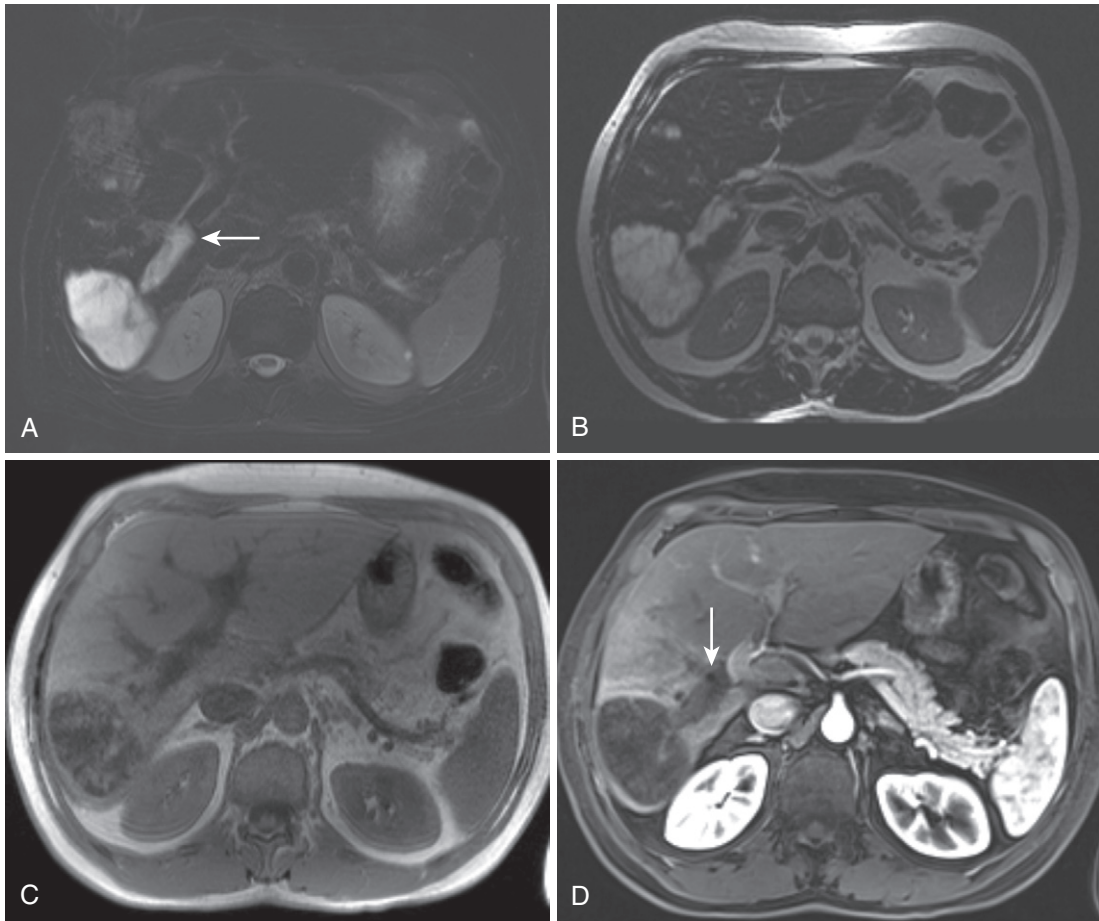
Liver infarction/infection due to chemoembolization. A, The moderately T2-weighted image demonstrates a markedly hyperintense, segmental roughly wedge-shaped lesion in the posterior segment of the liver with an adjacent tubular hyperintensity (*arrow*) at its apex—the thrombosed portal venous branch. Hyperintensity persists on the heavily T2-weighted image (B) with corresponding hypointensity on the T1-weighted in-phase image (C). D, Lack of enhancement of both the liver infarct and the thrombosed portal venous branch (*arrow*) is depicted on the contrast-enhanced image.
